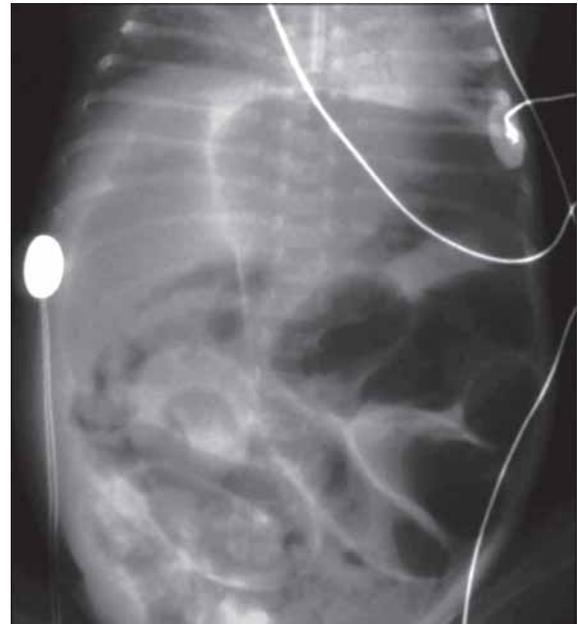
X-ray in meconium peritonitis. Note the calcification in right iliac region
